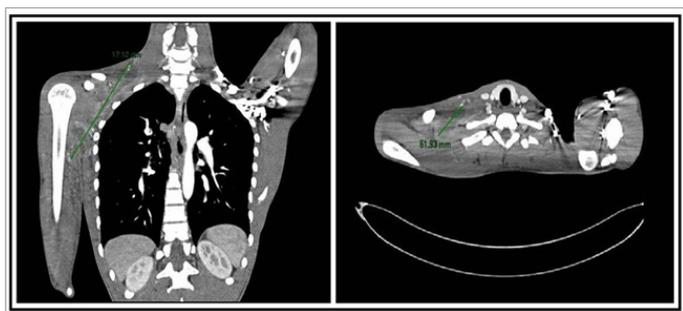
CT image on admission to hospital.
